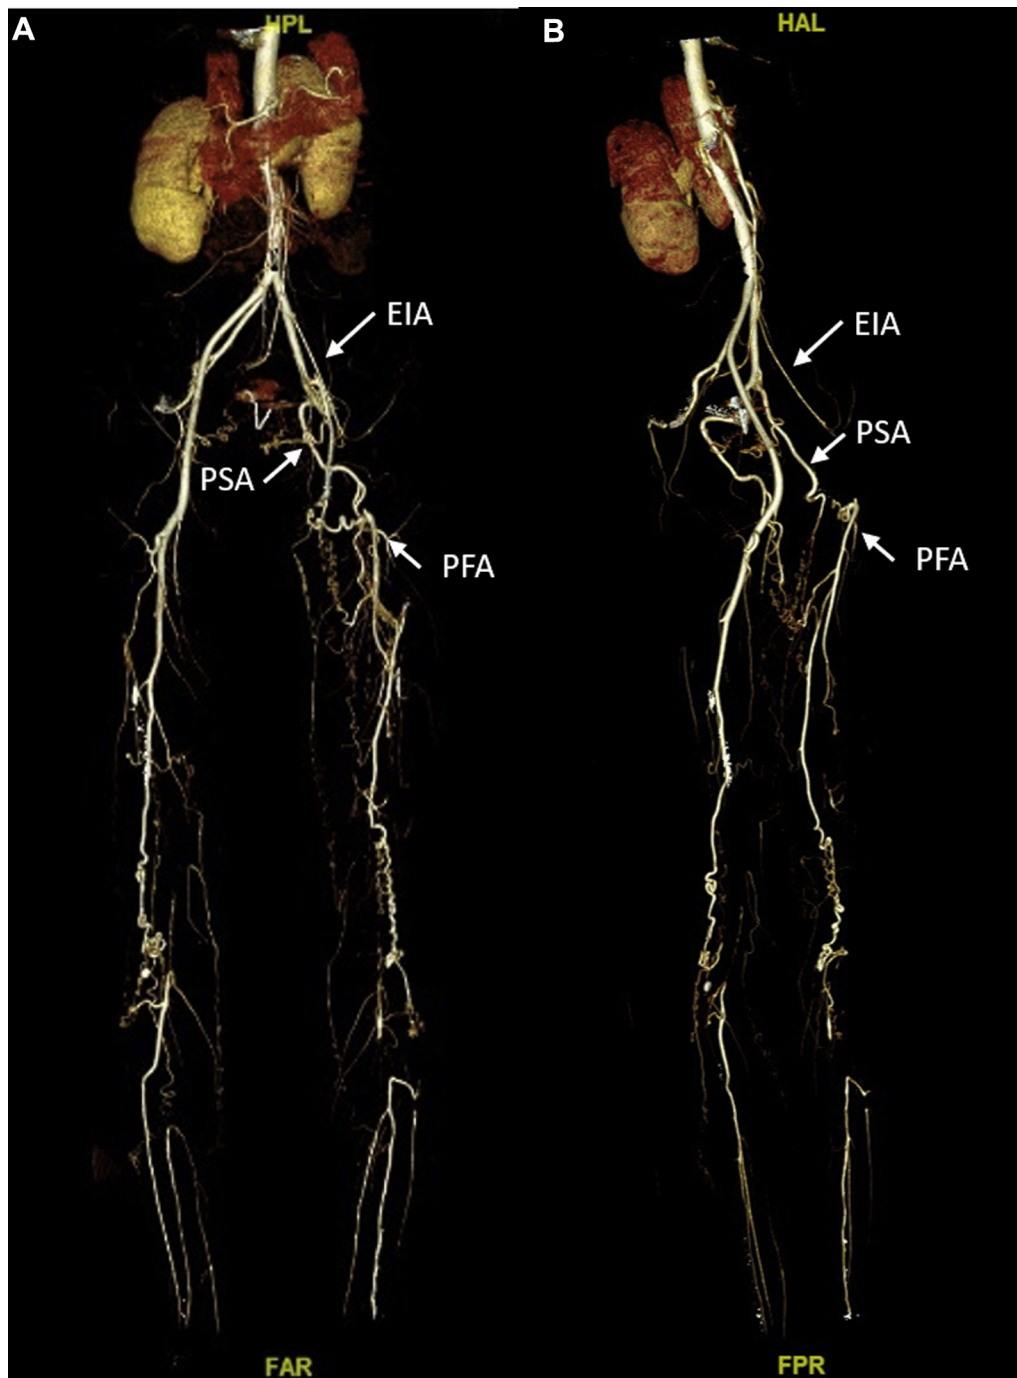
Preoperative computed tomography angiography (CTA) revealed that the left persistent sciatic artery (PSA) used collateral vessels feeding the left profunda femoris artery (PFA). The external iliac artery (EIA) was shrunk and occluded in the distal part. The common femoral artery (CFA), the superficial femoral artery (SFA), and the popliteal artery (PA) were totally occluded.
